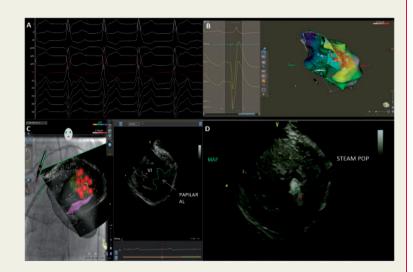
(A) Basal rhythm with suggestive morphology of origin in the anterolateral papillary muscle. (B) Electroanatomic map with 3D integration of the papillary muscle where the area of greatest precocity and QS unipolar morphology is observed. (C) Intracardiac ultrasound anatomy of the muscle and its integration in the map. Circumferential ablation applications are shown. (D) Steam pop during one of the applications in the muscle. The white arrow indicates the appearance of the lesion in the muscle. The yellow arrow shows the increase in bubbles formation due to the explosion. The red arrow points to the tip of the ablation catheter at that time
